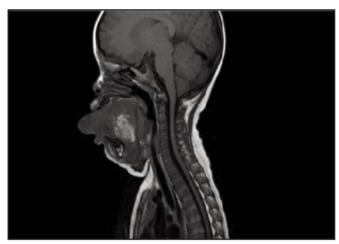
weighted MRI head and neck (sagittal) Shows haemorrhagic cystic lesion extending into base of tongue causing protrusion of tongue.
